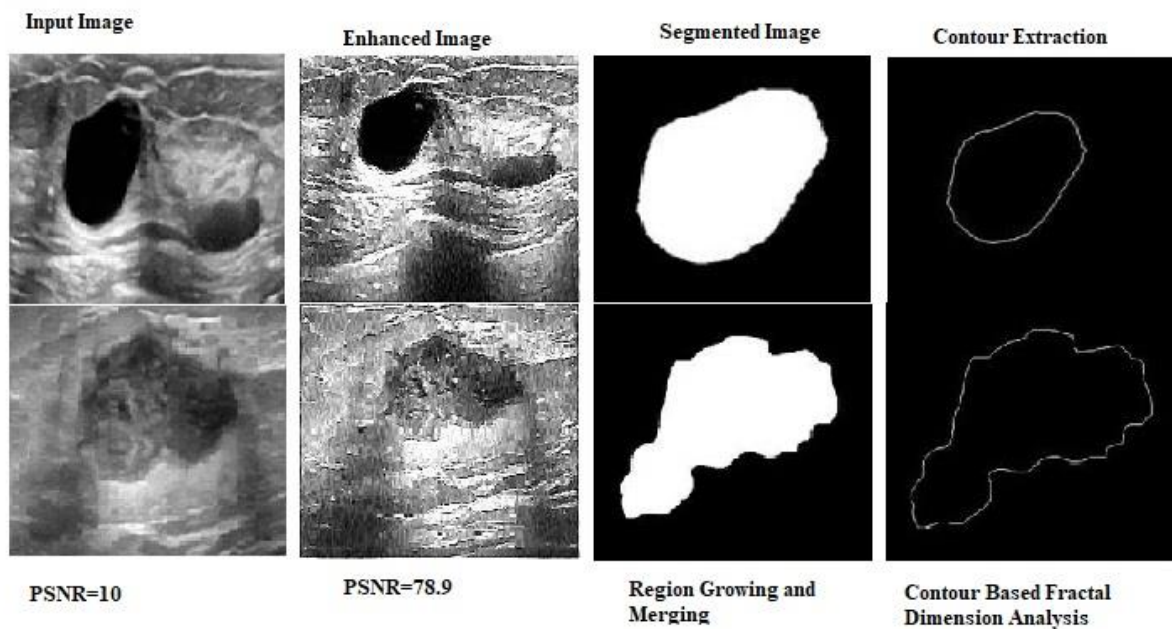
Extraction of Tumor and Contour in Ultrasound Images
